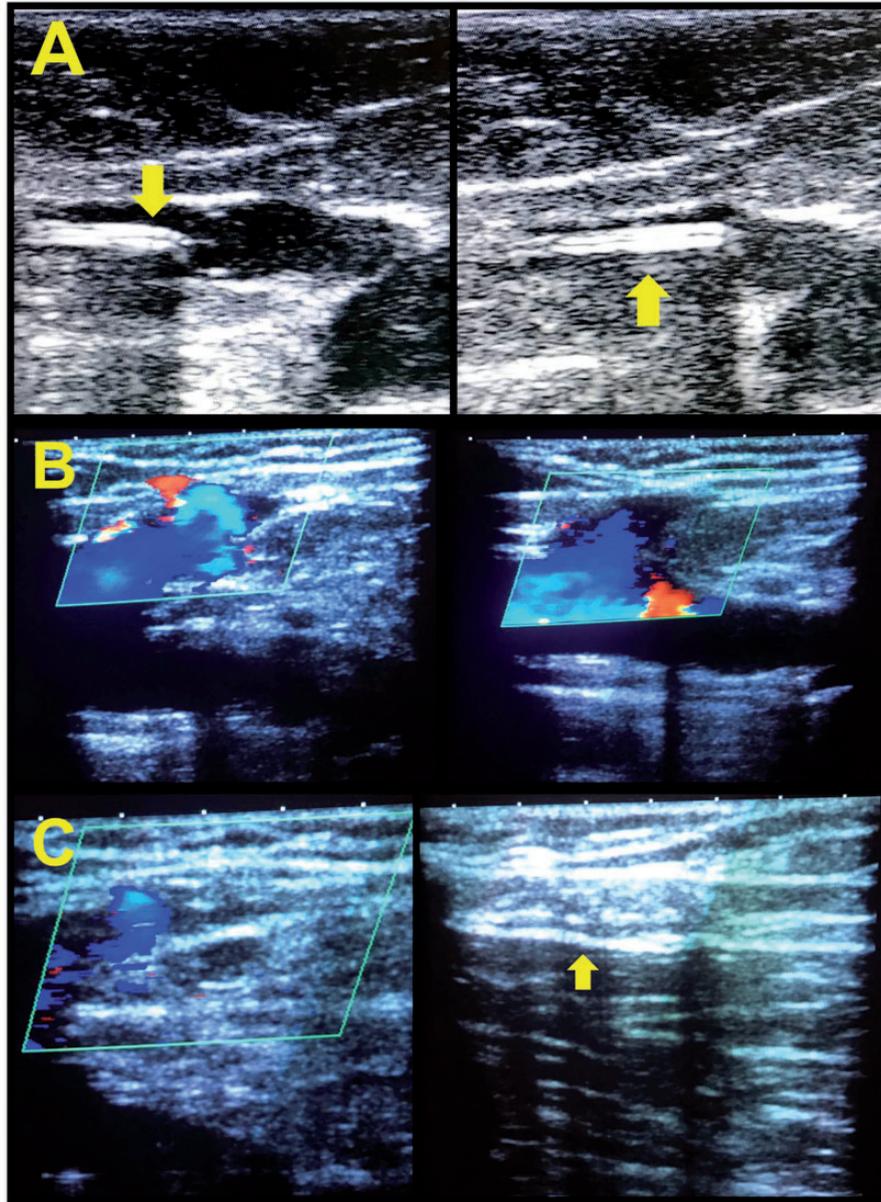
USG images of incompetent GSV (a) NBCA; VenaBlock catheter at SFJ, (b) after treatment with NBCA, and (c) color Doppler of SFJ after treatment.
